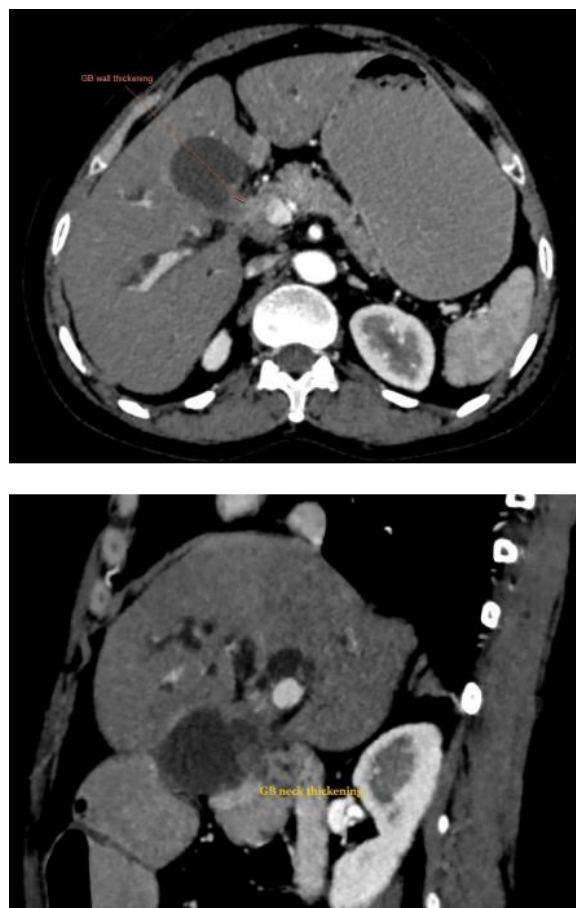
Contrast-enhanced CT demonstrating heterogeneously enhancing irregular wall thickening involving the neck of the gallbladder, extending into the proximal common bile duct (CBD) and common hepatic duct (CHD) through the cystic duct, with associated moderate intrahepatic biliary radicle dilatation.
